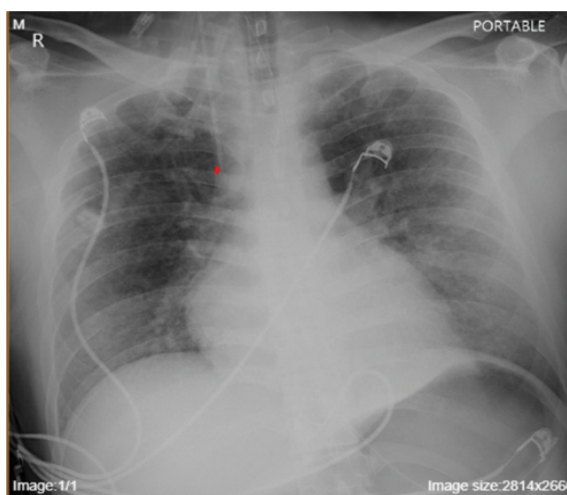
Resolution of chest X-ray changes after three days of IV Methylprednisolone 500mg OD.
